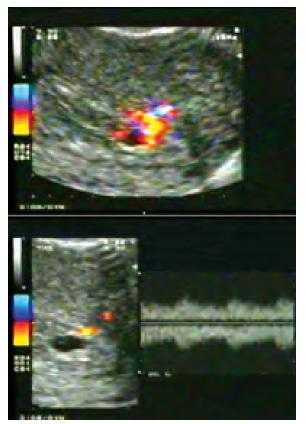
Image recorded by 2D color Doppler sonography, showing intervillous blood flow
